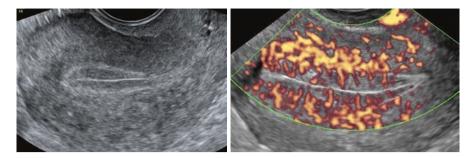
B-mode ultrasound showing a multilayered endometrium and power Doppler showing intra-endometrial blood vessels
